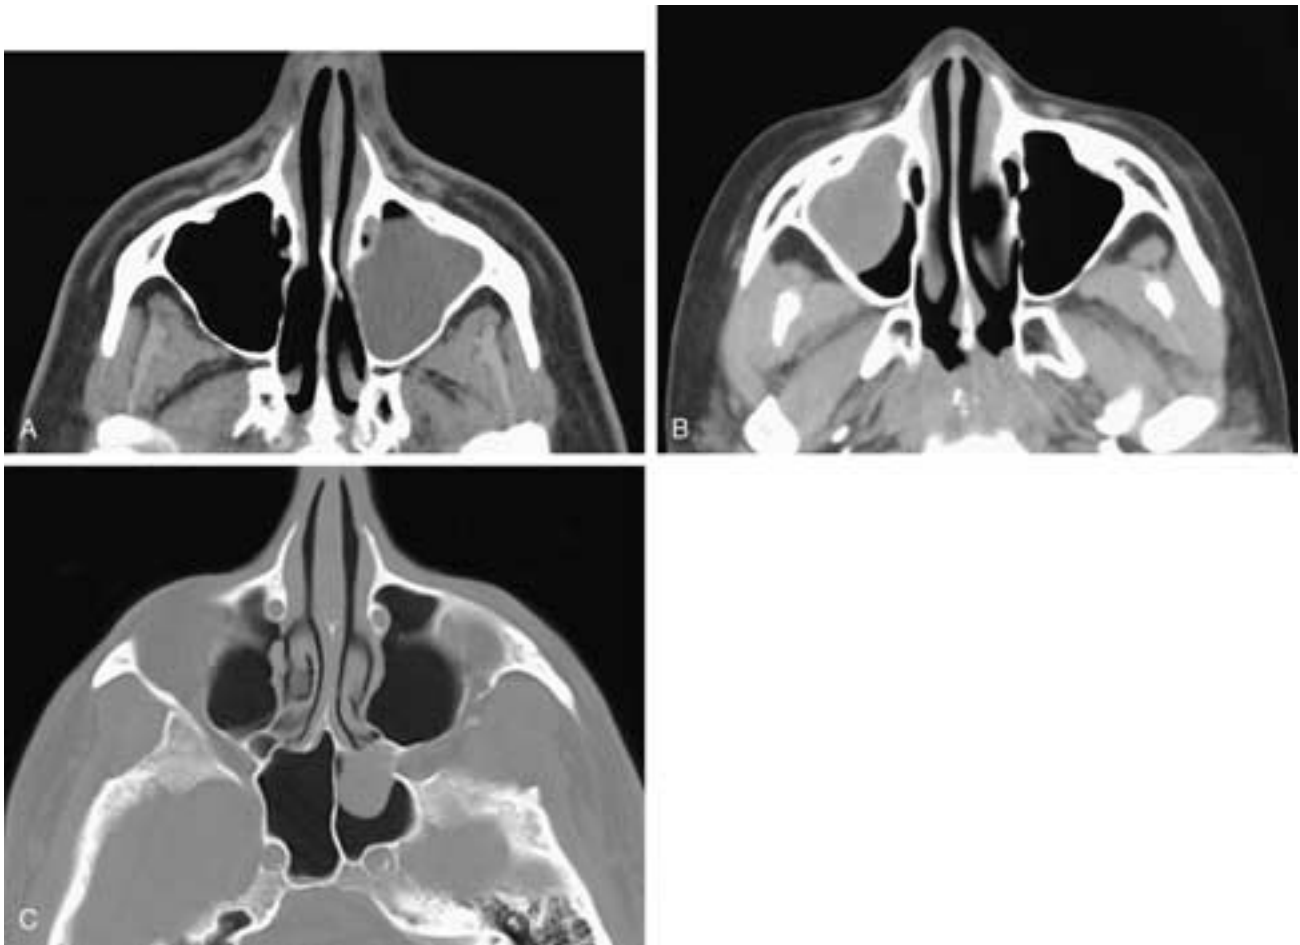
Axial CT scans. In A, there is a large retention cyst or polyp in the left maxillary sinus. A small amount of air is present over the upper surface of the lesion, and the sinus cavity is not enlarged. In B, there is a typical retention cyst or polyp in the right maxillary sinus. Note that the convex margin of the lesion is smooth and that the remaining sinus is normal. In C, there is a retention cyst or polyp in the left sphenoid sinus and minimal mucosal thickening in the right sphenoid sinus.
